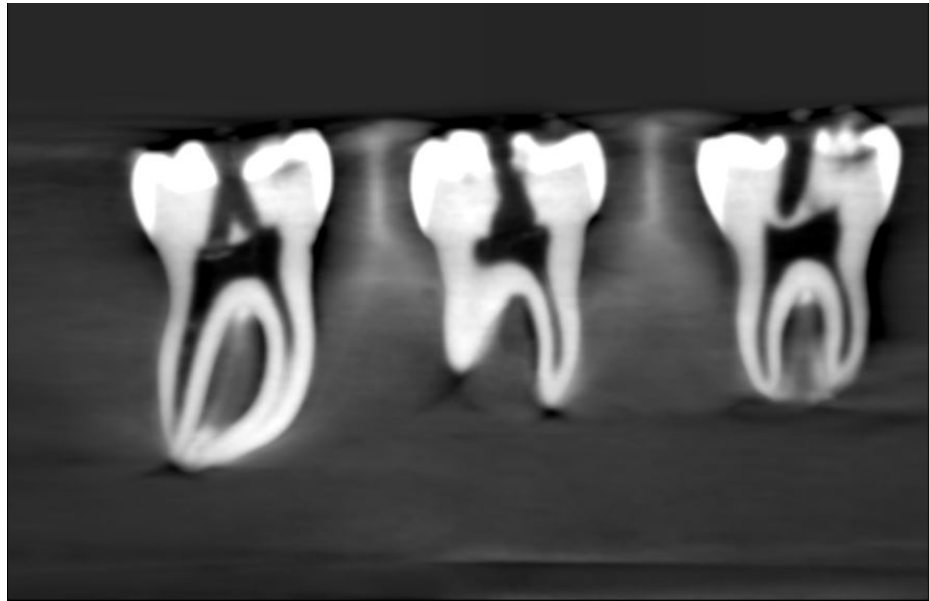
CBCT scan of accessed molars with crowns intact.
